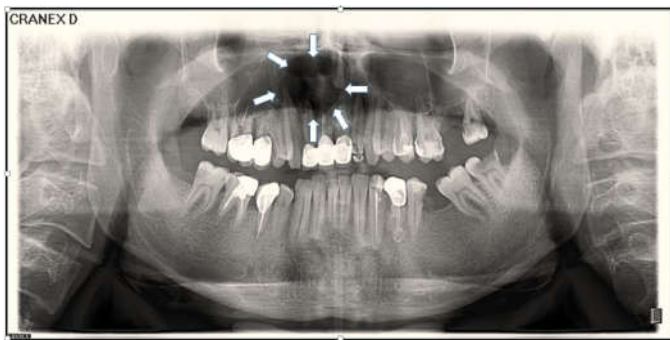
Panoramic radiograph. Arrows refer to the border of the cyst
